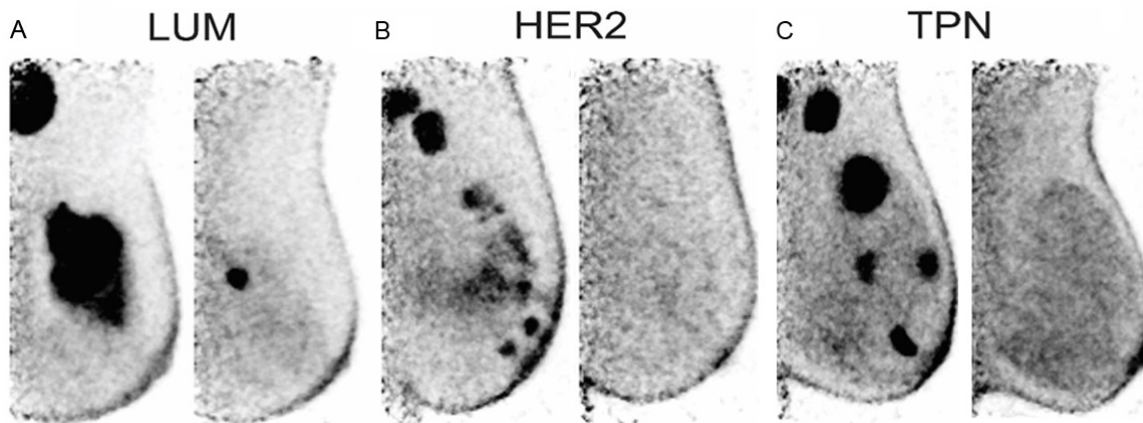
Semiquantification of chemotherapy response of the primary tumors by using both parameters of the ^{18}F FDG-uptake in the high resolution PEM. Images were obtained before and after the first course of NAC. For LUMA (A), PEM revealed 8.46 ± 32.99 for PUVmax and LTB, respectively. A significant reduction in both parameters was found after chemotherapy (PUVmax, 2.75; 8.43 LTB). Decreased values in PUVmax and LTB was also observed in HER2 (B), in which baseline and interim values of PUVmax and LTB were: 3.94 for PUVmax and 19.59 for LTB, and 1.11 for PUVmax and 5.28 for LTB. PUVmax and LTB values for TPN (C) were registered as follow: 4.27 for PUVmax and 20.13 for LTB (at the baseline), and 2.85 for PUVmax and 5.61 for LTB (after NAC). The ratio of the lesion's PUVmax to the average background value (LTB), was obtained brief, 2-cm circular ROI was drawn on the slice of around to target lesion, and the second ROI was drawn in a background area of normal breast tissue of the same breast. The position of this ROI was equal in both studies.
